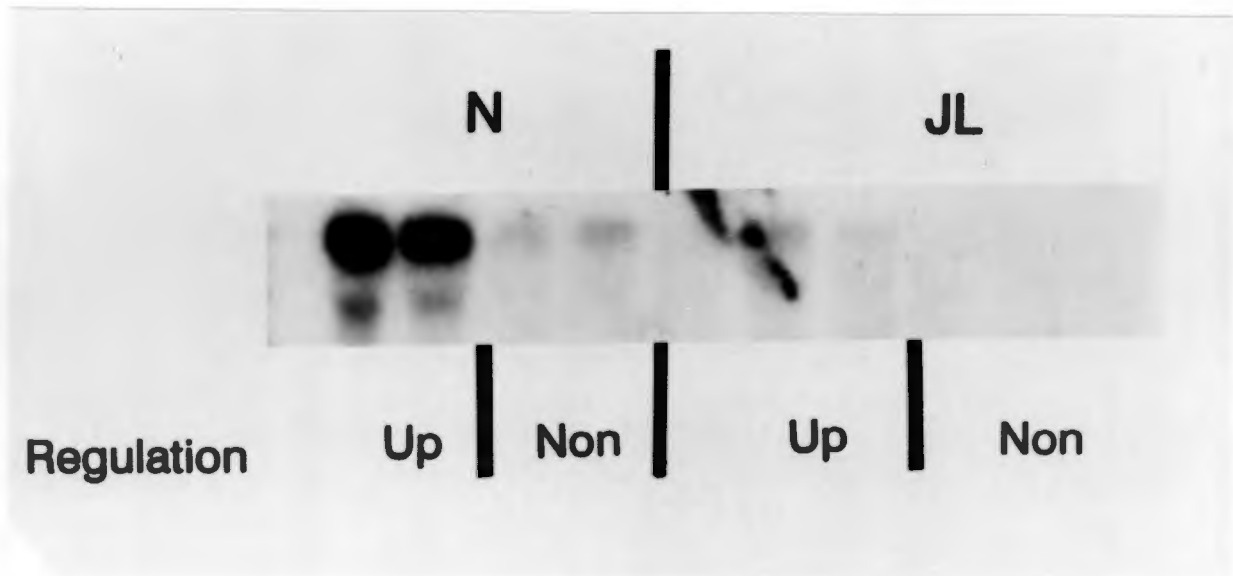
Northern Blot of LDL-receptor mRNA from normal and JL cells. Cells were grown for 5 days in Dulbecco's MEM containing 10% fetal calf serum. The cells were either grown in the same medium for an additional day (non-regulated) or were up-regulated in Dulbecco's MEM containing lipoprotein deficient serum (5 mg protein/ml). 30 ug of total RNA was electrophoresed in each lane of a 1% agarose gel containing 1x MOPS and 1% formaldehyde. The RNA was blotted onto HYBOND-N and hybridised with a probe to the LDL-receptor as described in the general methods and X-ray film was exposed to this membrane.
